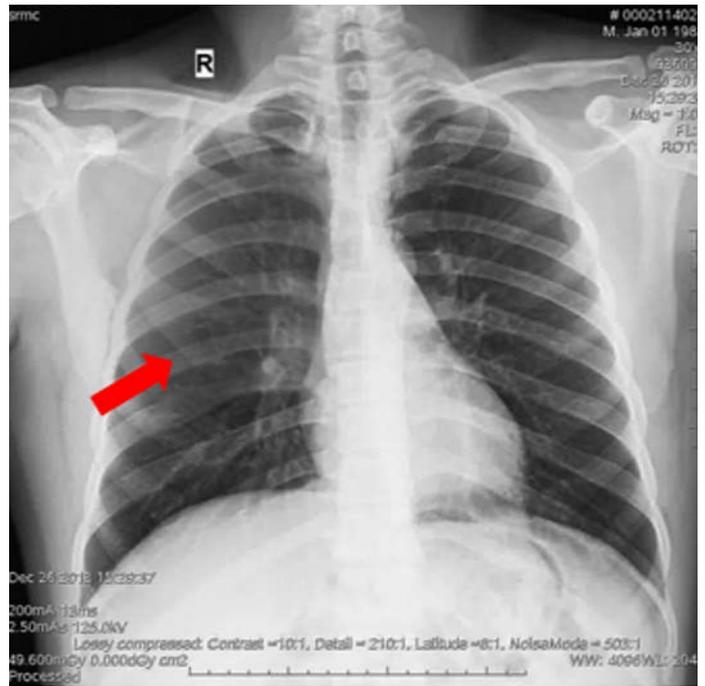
Chest radiograph showing bifid right third rib
